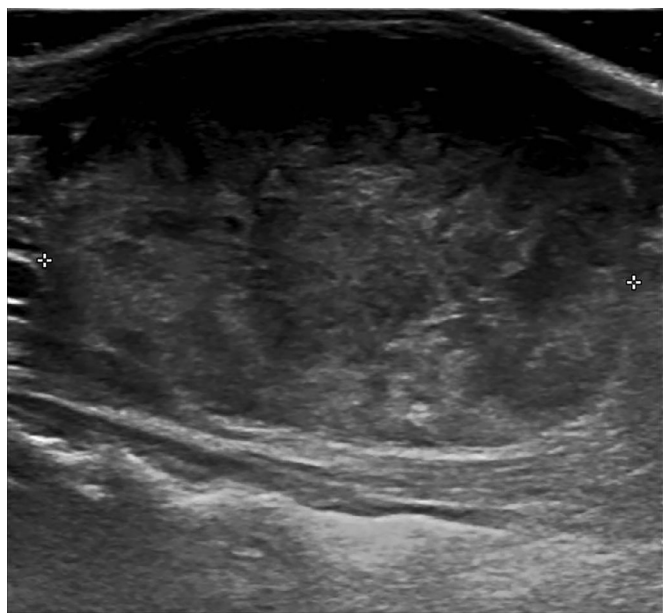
Ultrasound image of the mass (sagittal view).
